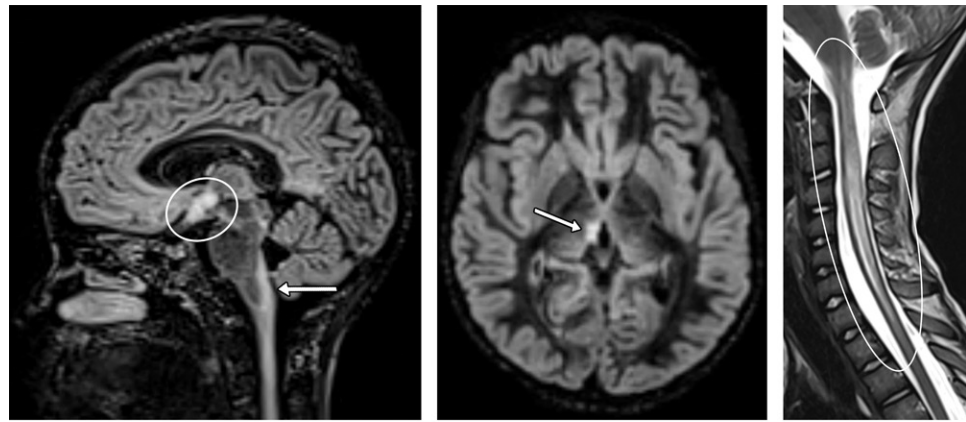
AQP4 antibody NMOSD in a 10-year-old boy with vomiting, unsteady gait, urinary incontinence, nystagmus, and diplopia. (a, b) Sagittal (a) and axial (b) double inversion-recovery images show typical brain involvement in the area postrema (arrow in a), optic chiasm (oval in a), and periependymal diencephalic region (arrow in b). (c) Sagittal T2-weighted image shows LETM (oval). (d) Axial T2-weighted image shows bright spotty lesions in the central area (arrowhead).
